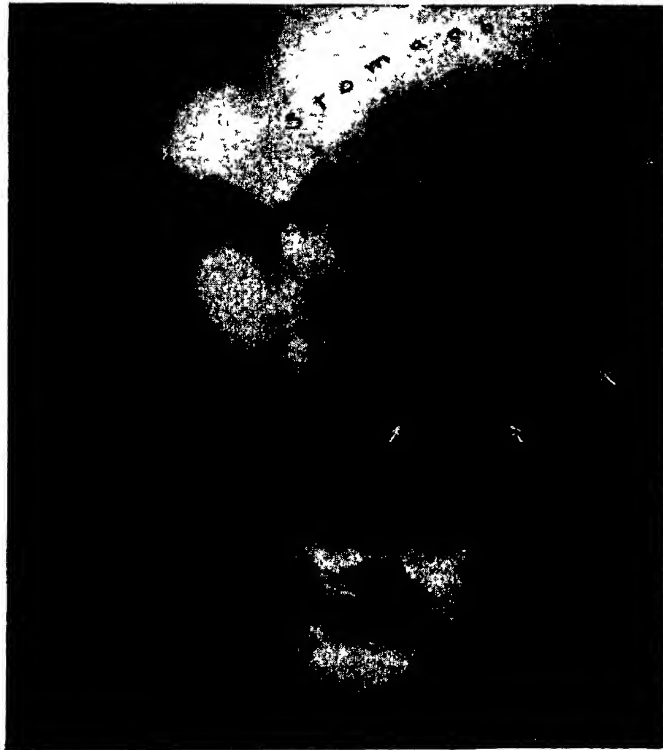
Case 5. Roentgenogram of duplication of stomach showing large mass outlined by arrows beneath stomach. Stomach is filled with barium and is dented along its greater curvature by mass (Ladd and Gross: Surg., Gynec. & Obst.)
